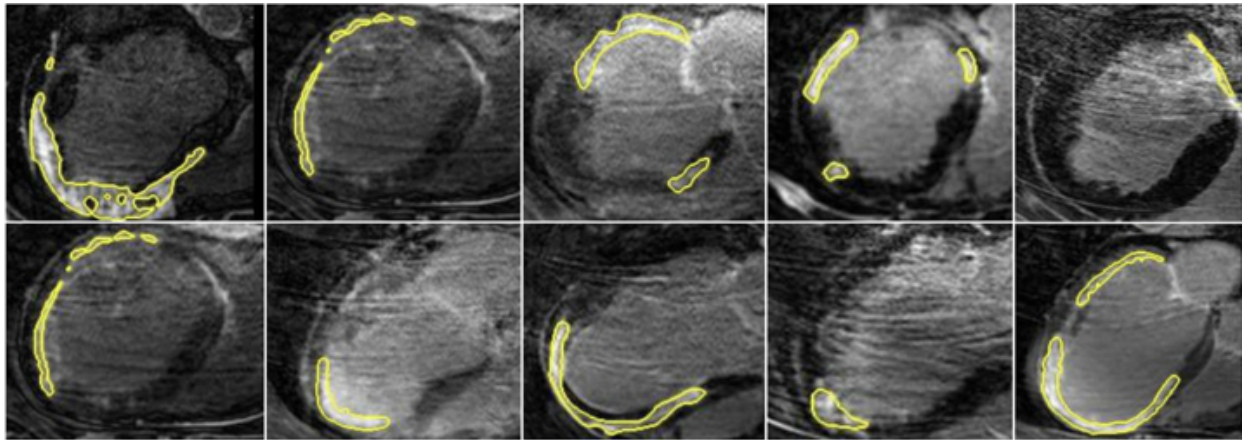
Varying size of scar from different patients in our dataset. Yellow contours represent the scar boundaries obtained using 3D LGE-MR images. Only single slices are shown in the images.
